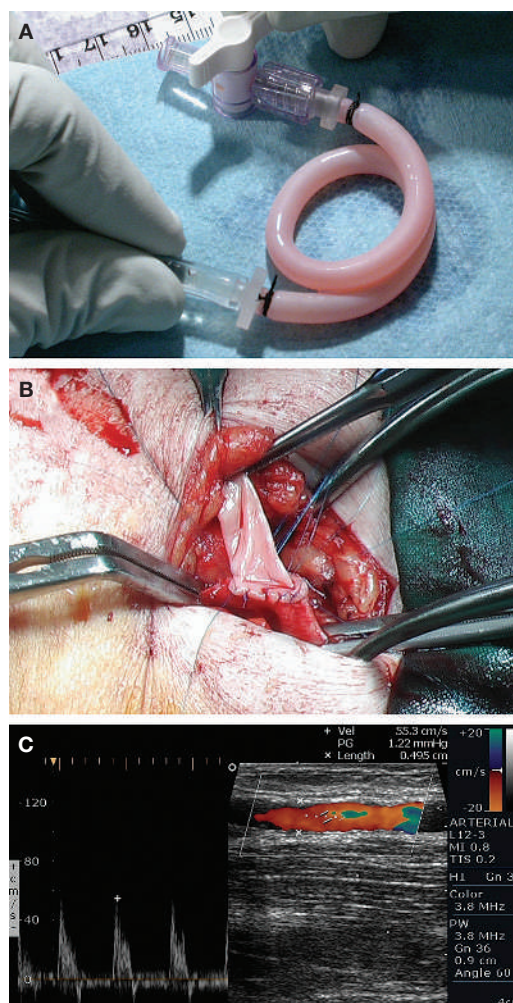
The first clinical use of a tissue-engineered blood vessel for high pressure arterial revascularization. (A) A completely autologous graft was implanted as an arteriovenous shunt between the humeral artery and the axillary vein. (B) The tissue-engineered blood vessel resembled native tissue and had normal surgical handling and suturing properties. The vessel synthesized met safety criteria and showed excellent flow under routine Doppler surveillance. (C) At 6 months, the shunt maintains high flow without signs of restenosis or aneurysm.
